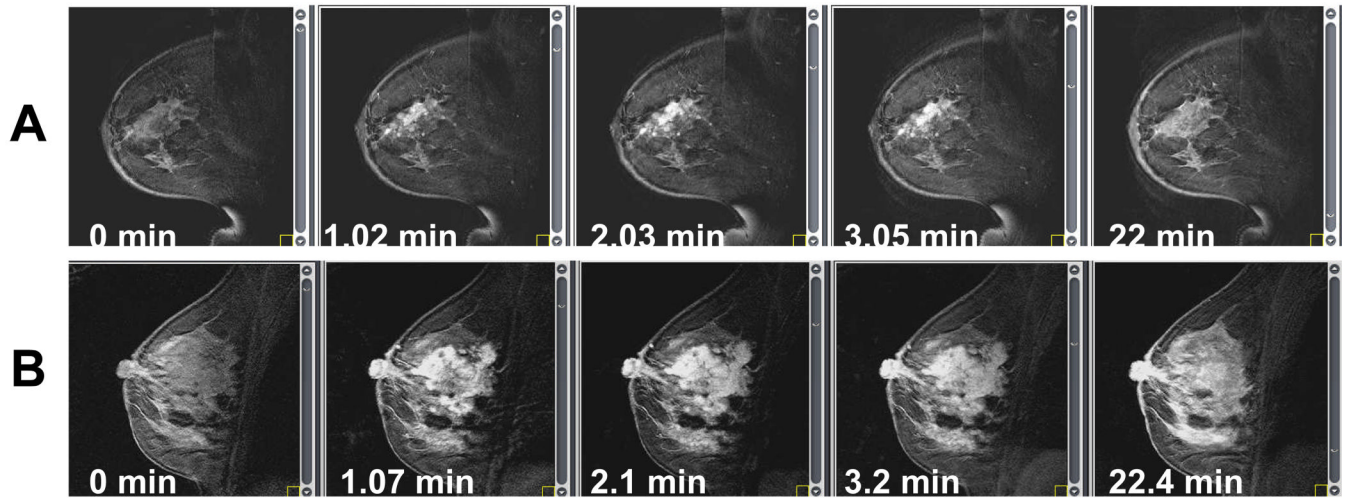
Sequence of DCE-MRI images taken before (time $t = 0$ min)) and after bolus injection of the contrast agent Gd-DTPA for two different patients: A) centrifugal enhancement, B) centripetal enhancement.
